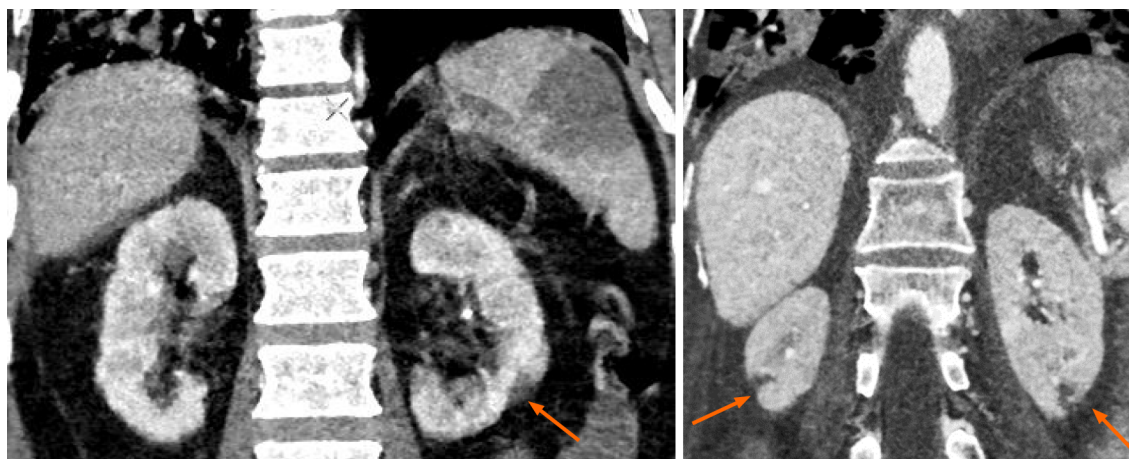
Solid organ infarction in a patient with coronavirus disease 2019. Coronal contrast enhanced computed tomography (CT) images of the abdomen show discrete, wedge-shaped non-enhancing renal parenchymal defects, with their apex pointing towards the medulla and base parallel to the subcapsular region (orange arrows), suggestive of renal infarcts. These were incidentally detected during CT pulmonary angiography.
